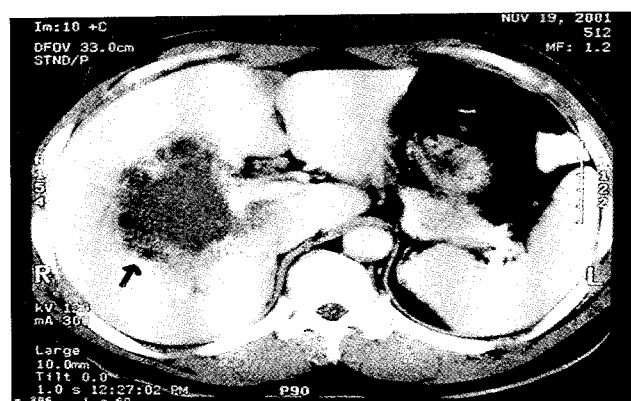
Follow up computed tomogram of the abdomen after one week showing an unorganized intra-hepatic hematoma (clinically presented as secondary infection of the hematoma).
